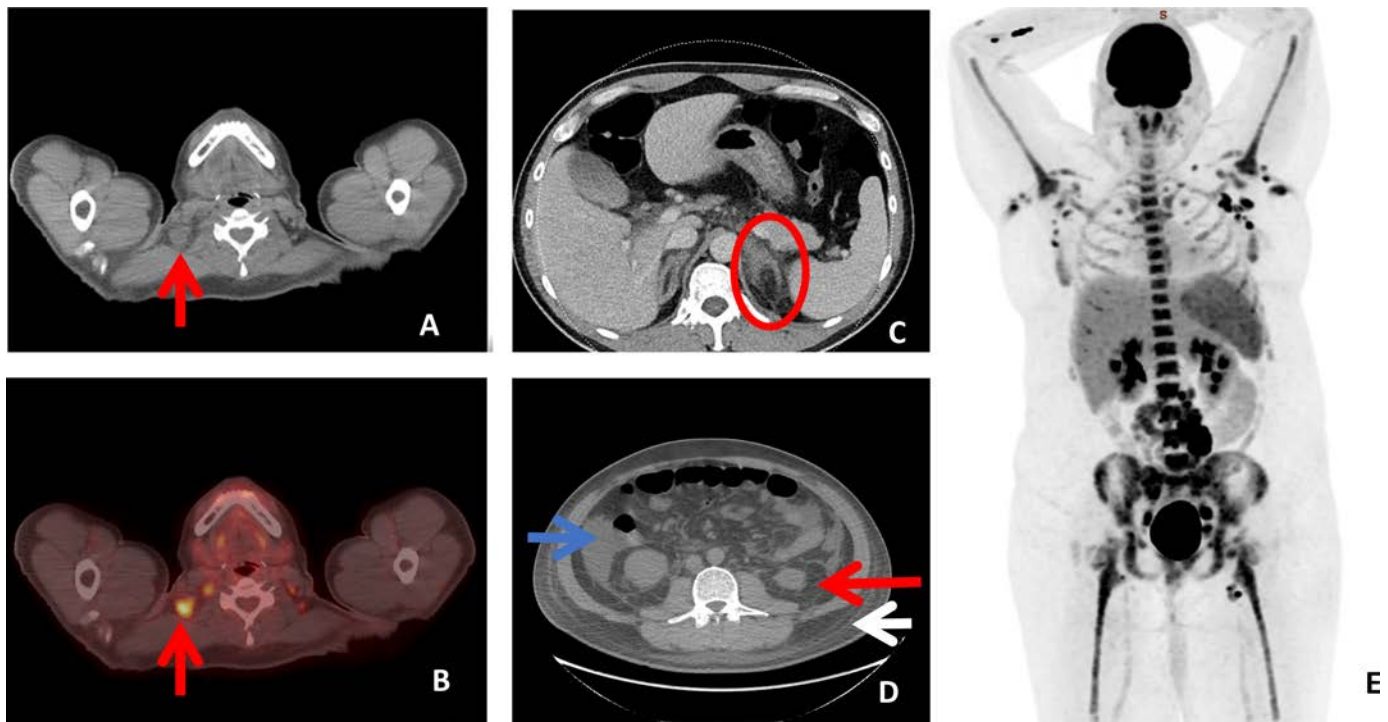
Radiologic findings in idiopathic multicentric Castleman disease (iMCD). (A) Cervical lymphadenopathy on computed tomography (CT) (arrow, largest lymph node). (B) Moderate 18 F-fluorodeoxyglucose positron emission tomography (PET) avidity (arrow) of lymph node in panel A. (C) CT scan showing prominent adrenitis with adjacent fat stranding (circle) in a patient with thrombocytopenia, anasarca, fever, renal dysfunction/reticulin fibrosis, organomegaly (TAFRO). (D) CT images demonstrating ascites (blue arrow), retroperitoneal standing (red arrow), and subcutaneous edema (white arrow) in a patient with TAFRO. (E) Diffuse axillary, intra-abdominal and inguinal moderately PET-avid lymphadenopathy in a patient with iMCD—not otherwise specified. Source: courtesy of Drs Don Wilson and Steve Burrell.
